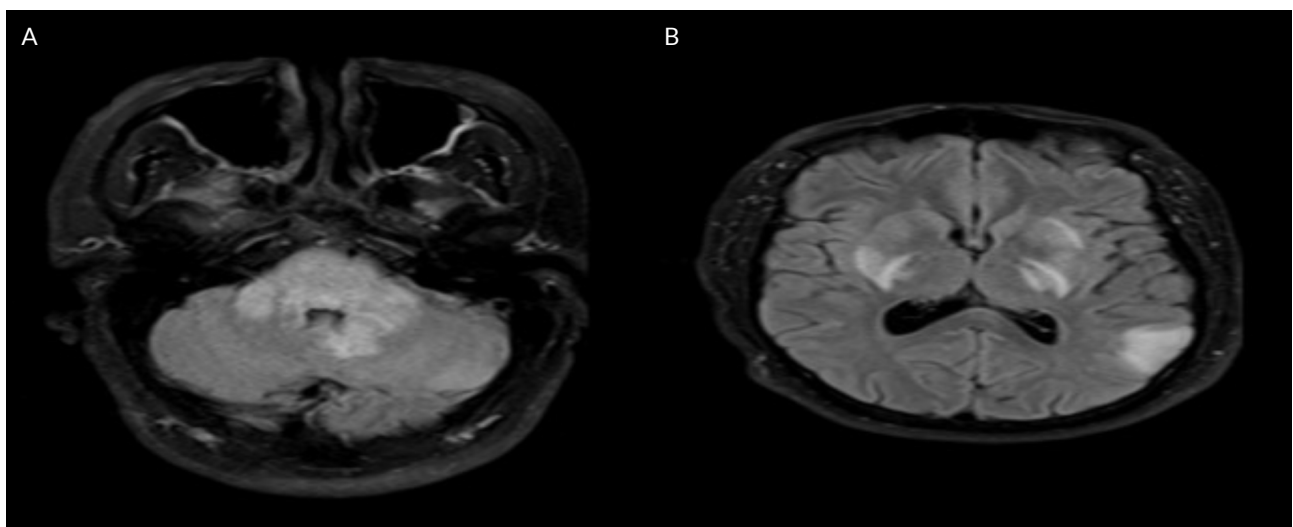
Brain magnetic resonance imaging. A) In the axial FLAIR-weighted sequence, hyperintense lesions with expansive features were observed in the pons bilaterally involving the cerebellar peduncles and extending into the left cerebellar hemisphere; B) Hyperintense lesions were observed in the bilateral basal ganglia at the level of the posterior limb of the internal capsule and in the cortex-subcortical white matter of the left parietal region.
